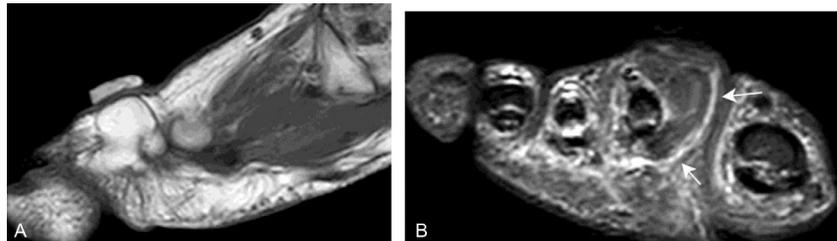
Lipoma. (A) Sagittal T1WI shows a lobulated superficial mass at the dorsum of the second toe which is iso in signal to the subcutaneous fat. (B) On coronal short-axis postcontrast fat saturated T1WI, the mass shows peripheral rim enhancement (white arrows) with iso signal to the subcutaneous fat. T1WI, T1-weighted images.
